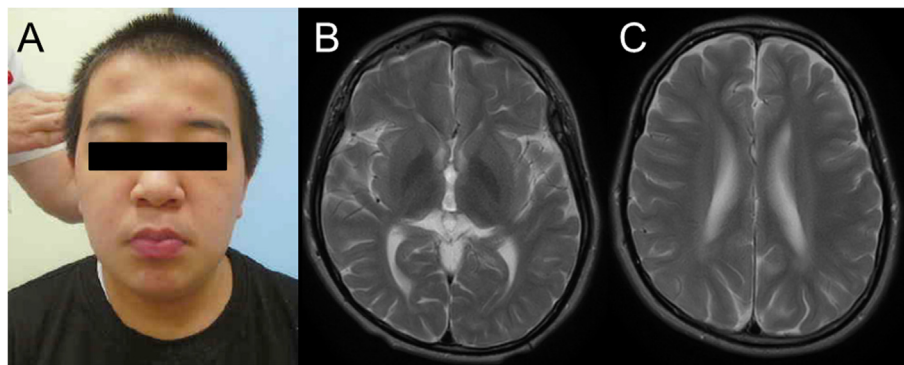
Clinical information of the patient. (A) The patient showed coarse facial features with subcutaneous nodules. Written informed consent for use of this photo has been obtained from his parents. (B) Brain magnetic resonance imaging shows decreased T2-intensity in the thalami. Mild T2-high intensity is diffusely observed in the white matter.
